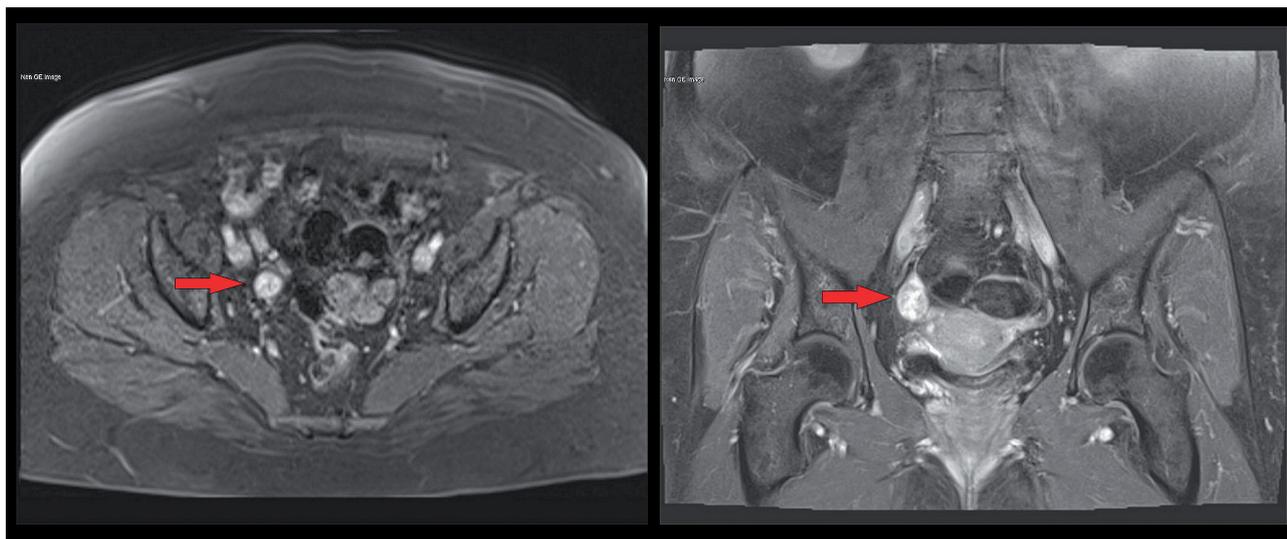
MRI showing a 15×13-mm solid tumour of the right ovary.
